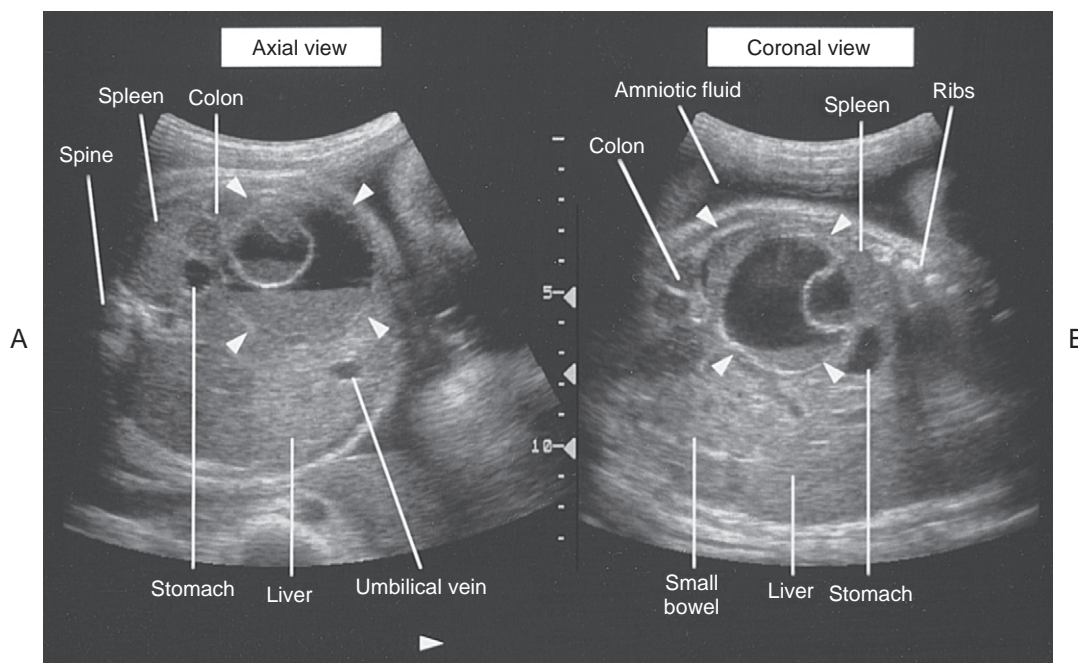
A and B, Two views of an ultrasonogram of a fetus in the third trimester. A large, complex ovarian cyst containing fluid debris, internal septation, and solid components can be seen (arrowheads). An ovarian neoplasm was identified during surgery after birth. (Courtesy Gary A. Thieme, MD, Prenatal Diagnosis Center, University of Colorado School of Medicine.)
